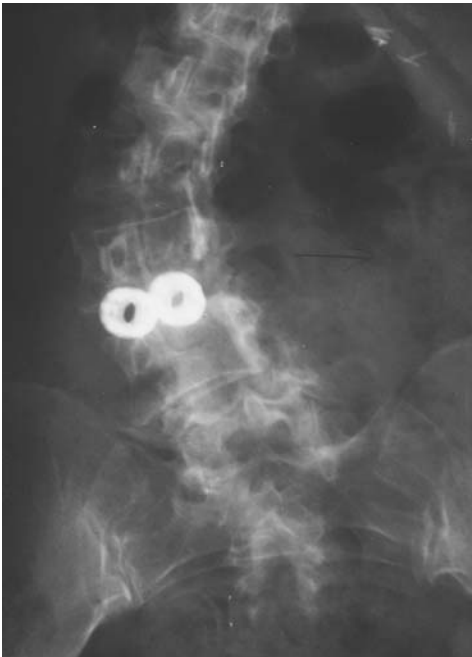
Radiographs reveal a transfer lesion at L4–5 with lateral olisthesis.
